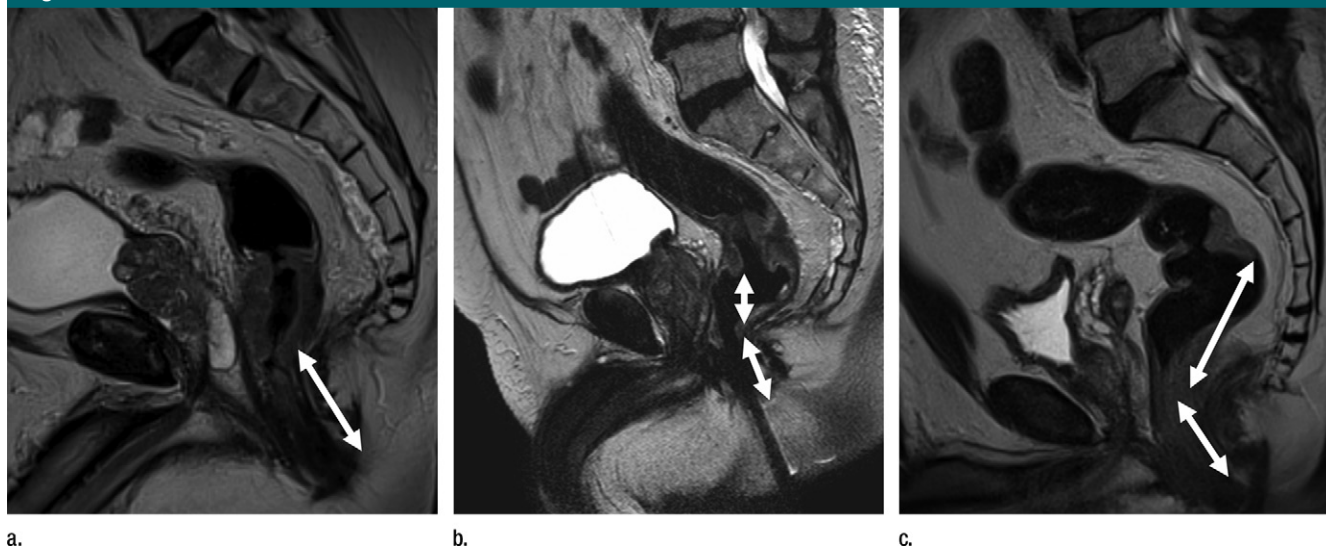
Sagittal T2-weighted images in different patients with rectal carcinoma show distance (arrows) from the anal verge in (a) low rectal, (b) midrectal, and (c) upper rectal tumors (low rectal tumor, <5 cm; midrectal, 5–10 cm; upper rectal, >10 cm). The measurement must be performed in a relatively straight line to produce similar measurement to that undertaken with rigid sigmoidoscopy.
